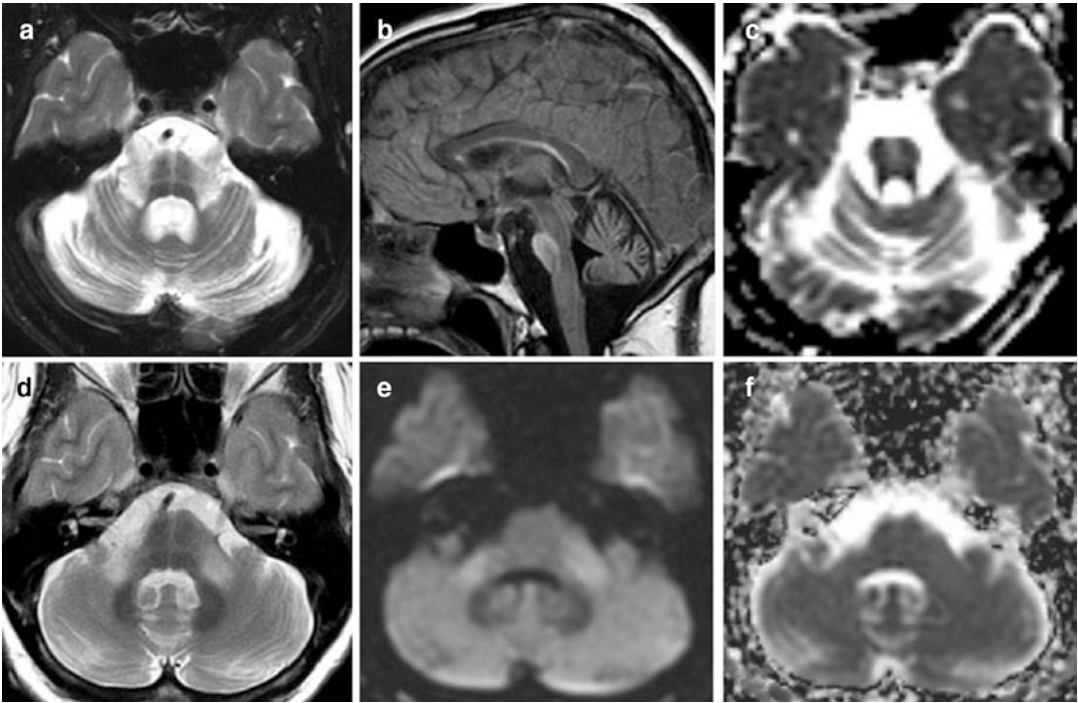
53-year-old woman with a 5-year history of gradually progressive cerebellar ataxia, dysarthria, and balance difficulties. Axial T2 with hot cross bun sign (a), sagittal FLAIR with pontine atrophy and hyperintensity
